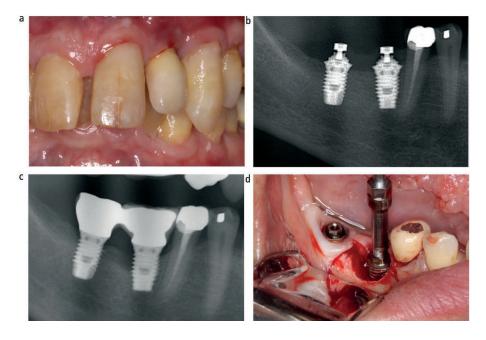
(a) Peri-implant mucositis; cleaning is poor and there is gingival inflammation present in association with the natural central incisor tooth and the lateral incisor implant unit. (b-d) Progressive bone loss associated with an implant with peri-implantitis. There is an interval of 2.5 years between the radiographs. An implant retrieval tool is being used to remove the failing implant
